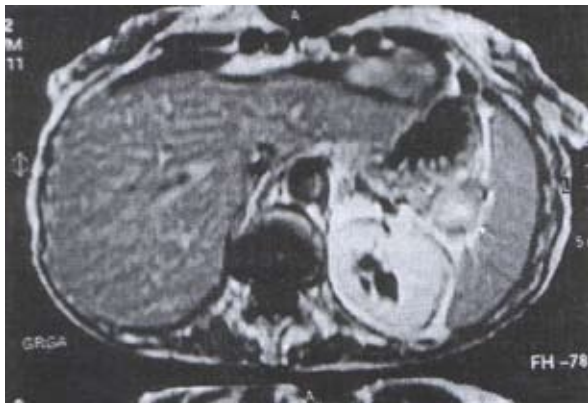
MRI of glucagonoma: the coronal T2-weighted image of the abdomen after IV-applied contrast, depicting the tumor mass as a high-intensity abnormality (3.0 cm × 2.5 cm) in the tail of the pancreas, lying at the splenic hilum.
